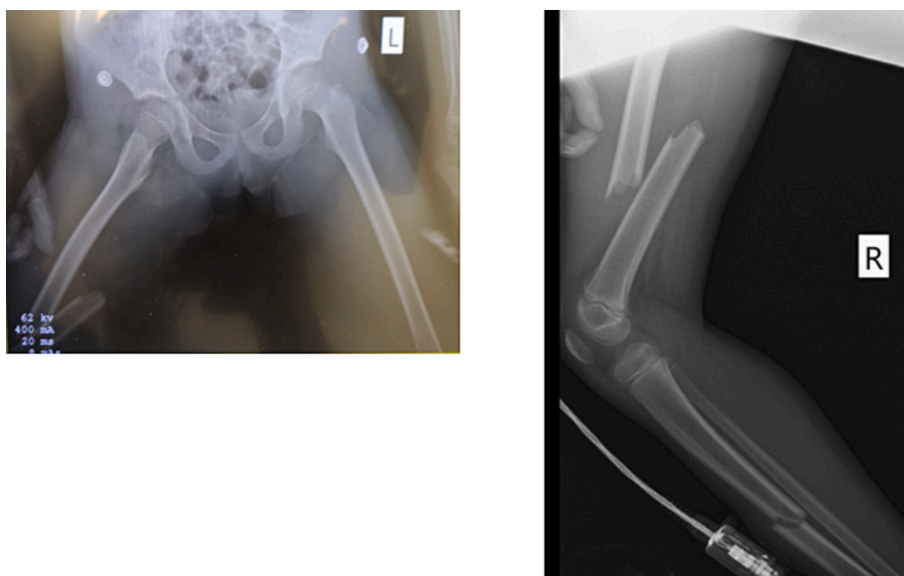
(a) Anterior-posterior and (b) lateral x-rays of the Floating Knee type fracture on the day of injury.
